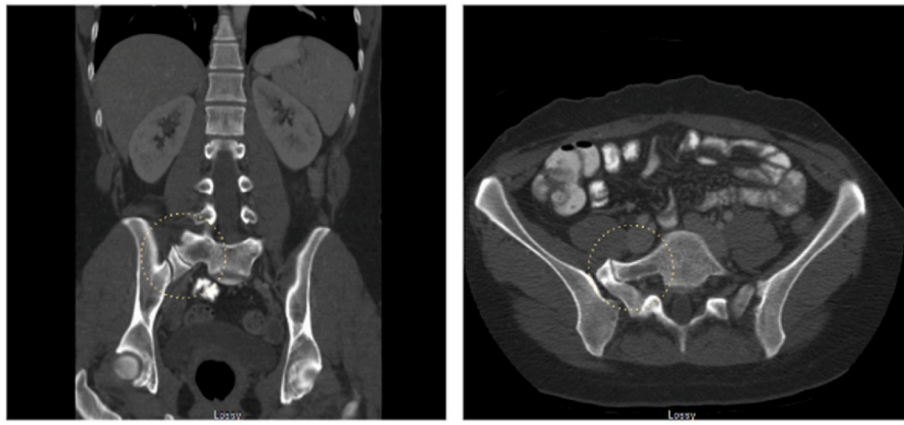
Right sided Bertolloti segment on Coronal and Axial CT Abdomen and Pelvis with Contrast.
